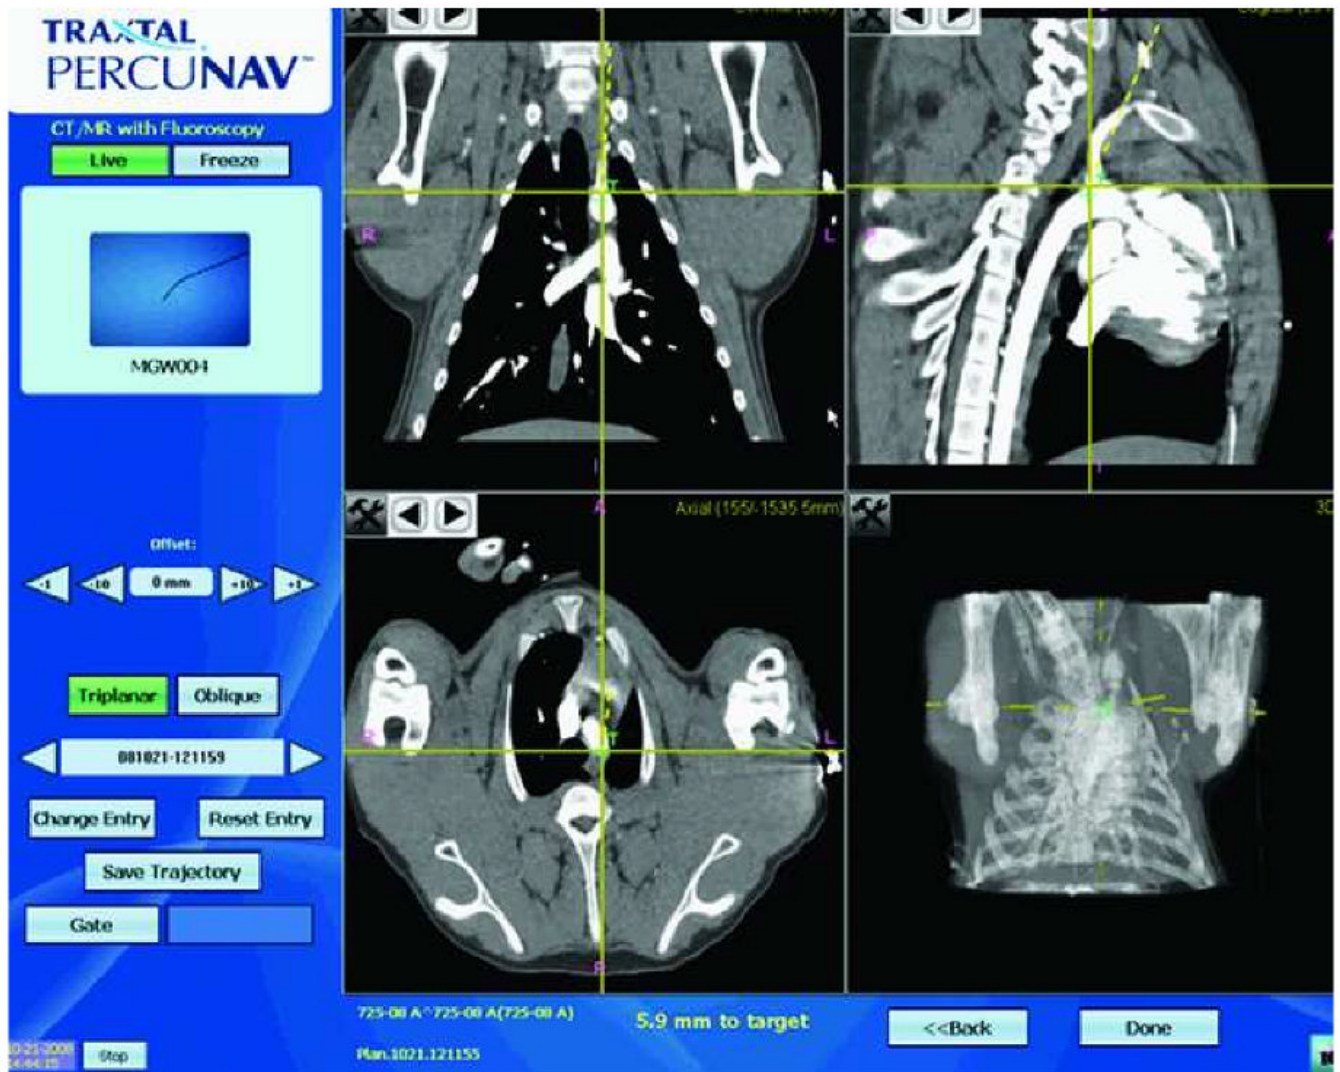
Graphical user interface for electromagnetic-guided navigation. The screen display (Traxtal Inc., Toronto) shows the tracked tool (left upper corner), in this case an angled guidewire (large black arrow). The yellow crossing lines on each panel indicate the position of the tracked sensor coil. The target “T” is displayed as a small green cross on the pre-procedure CTA. Each panel shows the position of the tracked tool in relation to target in one of the three planes, sagittal, coronal and axial as well as a 3D view. The dotted yellow line indicates the direction the tracked tool. The distance to the target in mm is also shown at the bottom of the screen. The position and orientation of the tracked tool and the distance to target is updated real time.
